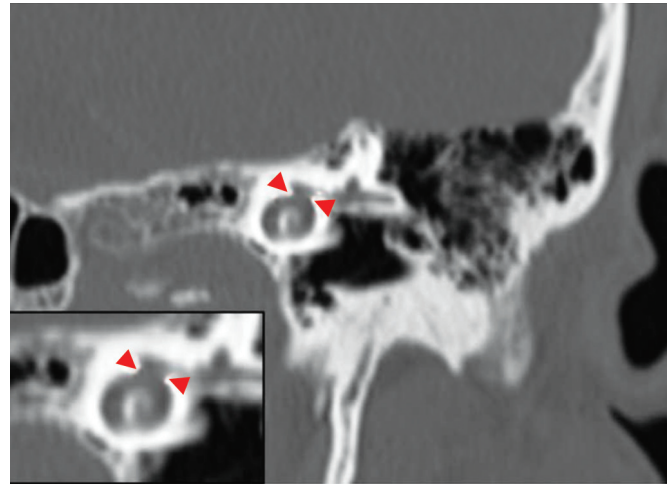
Computed tomography (CT) scan (coronal section) of the left ear. There is merging of the facial canal and cochlea (arrowheads). *Source:* Adapted with permission from Blake et al.⁷
